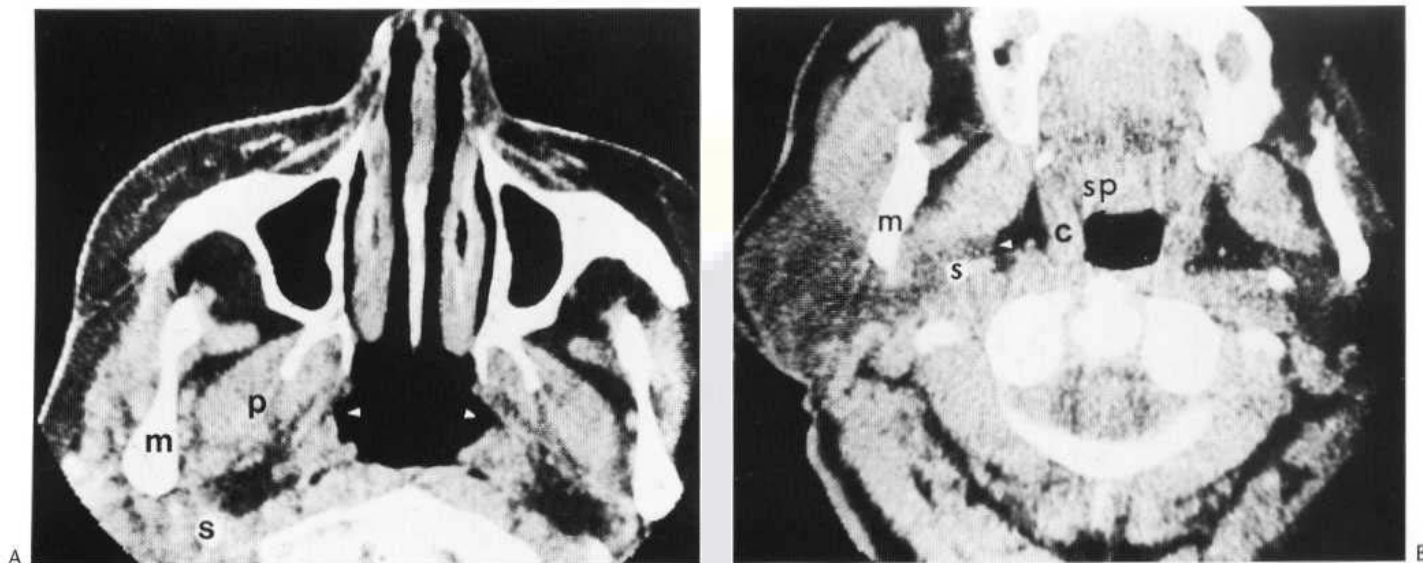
Axial CT of soft tissues below the skull base. (A) Normal section through antra and postnasal space. The arrowheads indicate the openings of the eustachian tubes. m = ramus of mandible; s = styloid process; p = pterygoid muscles. (B) Section at a slightly lower level passes through the soft palate (sp). Tensor and levator palatini blend with the pharyngeal constrictors (c) to give a dense muscle mass. The enlarged but otherwise normal parotid gland has a lower attenuation, i.e. appears darker, than the masseter muscle in front of it but not as dark as the fatty tissue in the parapharyngeal space. Thus the medial limit of the deep parotid lobe can be defined (arrowhead). These features are best shown by MRI.
